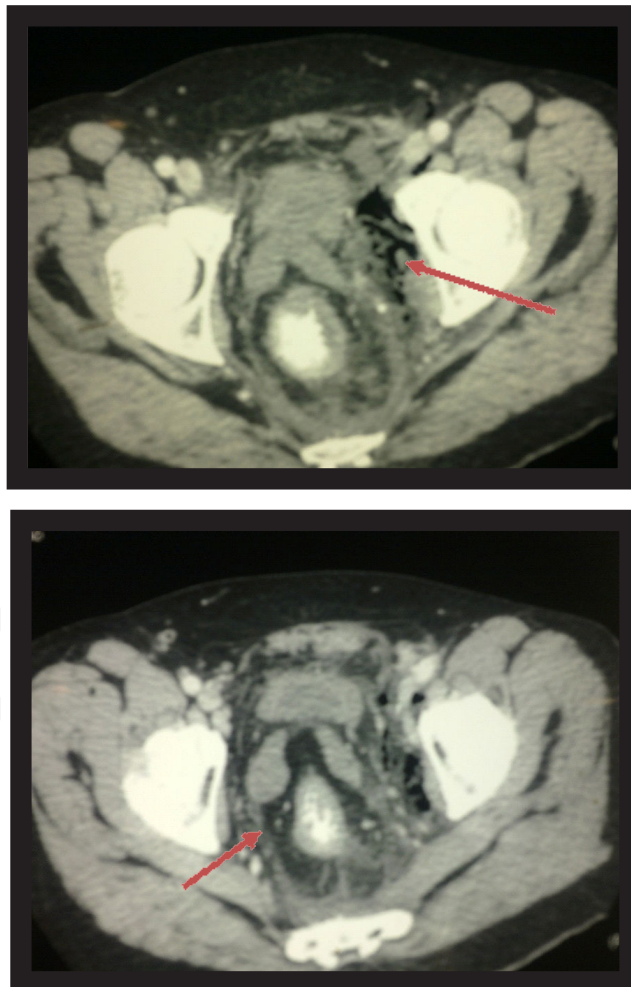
CT pelvis demonstrated collection in the bilateral ischio-rectal fossa, with gas in the perirectal region extended to the high pelvis
